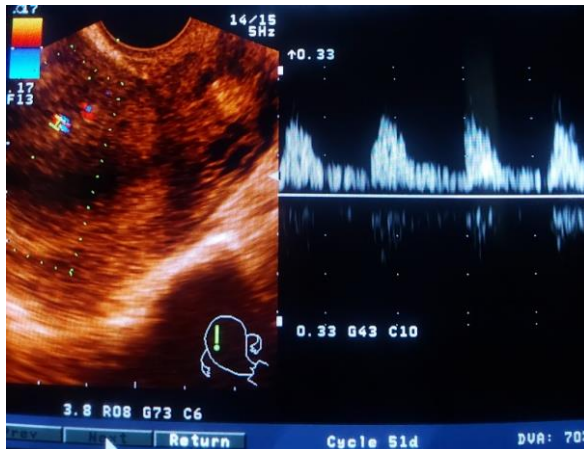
Arterial spectral Doppler flow recording
